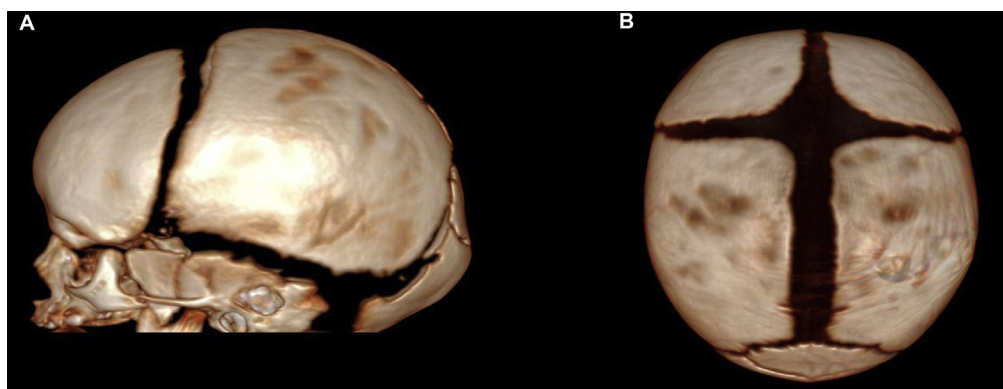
Cranial sutures depicted on 3-dimensional reconstruction computed tomography images of a 7-day old male infant.
